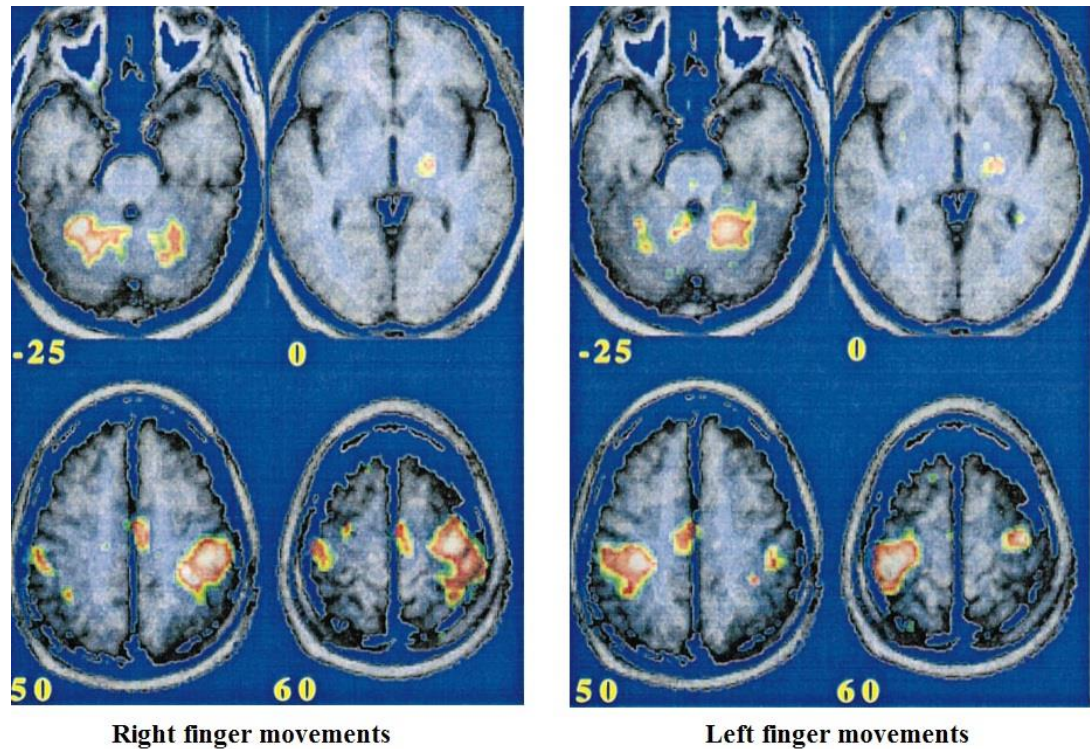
PET/MRI superimposition. PET data for t-values during right finger movements and left finger movements displayed on a color scale (white > 10, red > 5.41, yellow > 4.79, and green > 3.50) superimposed onto the averaged transformed MRI data. This figure is edited based on the figures adopted from [5] with courtesy.
